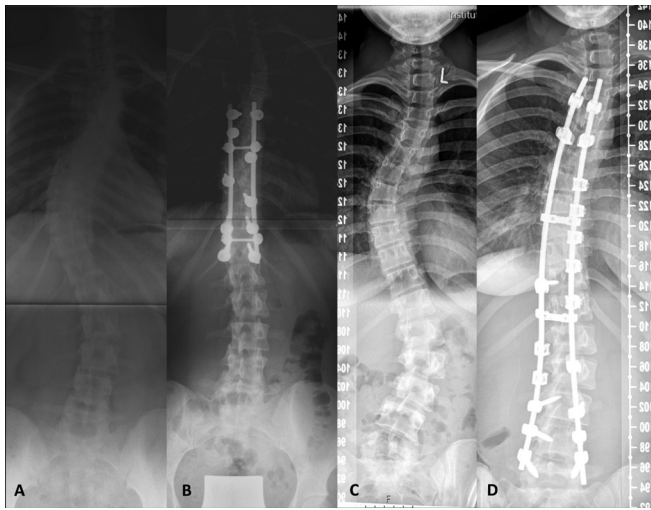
Example full-spine radiographs of a patient treated with selective fusion (A, presurgery and B, postsurgery) and a patient treated with nonselective fusion (C, presurgery and D, postsurgery).
